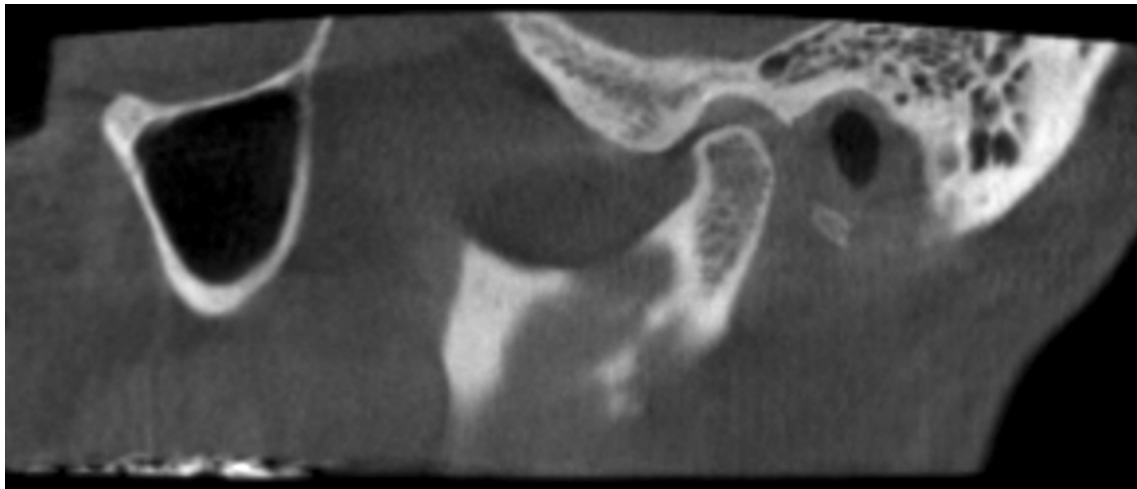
Female, 66. Oblique sagittal CBCT view shows condylar flattening and sclerosis in the fossa/ eminence area, interpreted as indeterminate for osteoarthritis. CBCT, cone beam CT.
